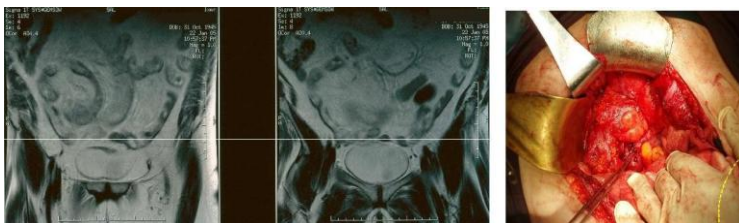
MRI aspect of leiomyosarcoma. Intraoperative aspect /
